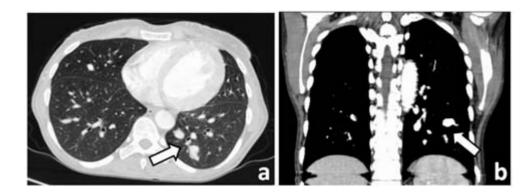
Thorax CT showing bilateral saccular and fusiform intraparenchymal aneurysmatic dilations of pulmonary vascular structures (white arrow) (a) sagittal plane and (b) coronal planes.
